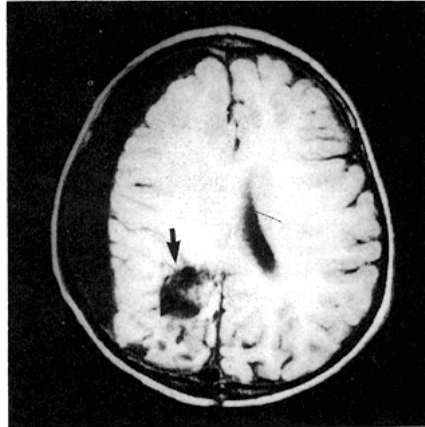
T1-weighted magnetic resonance image, 8 months after surgery. Only a small cavity (*arrow*) was seen.
